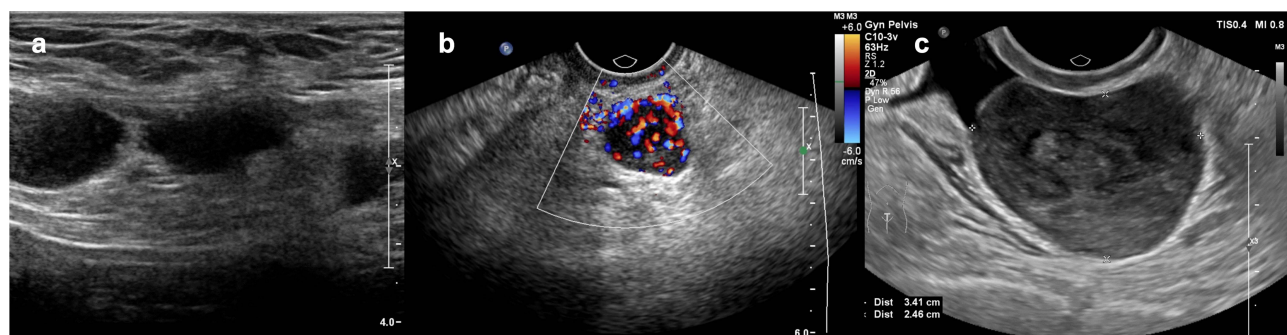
Ultrasonography showing multiple irregular hypoechoic lesions with clear borders (a) and rich blood flow (b) in the lower abdominal wall. A well-defined heterogeneous nodule with rich blood flow measuring 3.4×2.8×2.5 cm was identified in the anterior aspect of the rectum (c).
